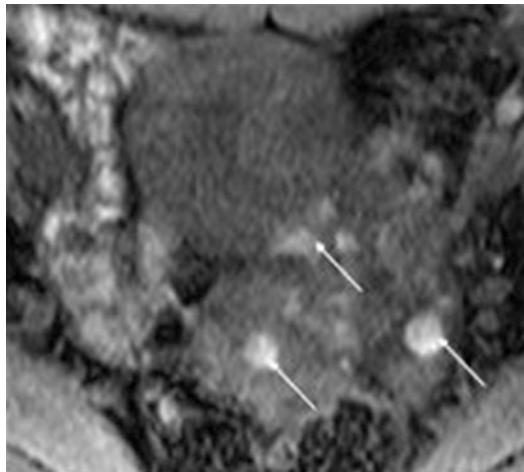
Endometriosis in the left lower quadrant. Axial T1-weighted MR image of a 25-year-old woman presenting with left lower abdominal pain shows multiple hyperintense serosal endometriosis deposits involving the sigmoid colon (arrows), the cause for her acute pain, which potentially could be confused with diverticulitis
